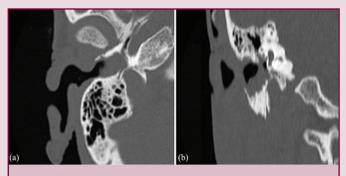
Axial (a) and coronal (b) views of computed tomography of petrous temporal bones showing an erosive mass of the right external auditory canal (EAC), extending into the middle ear with erosion of the anterior and inferior EAC walls.
